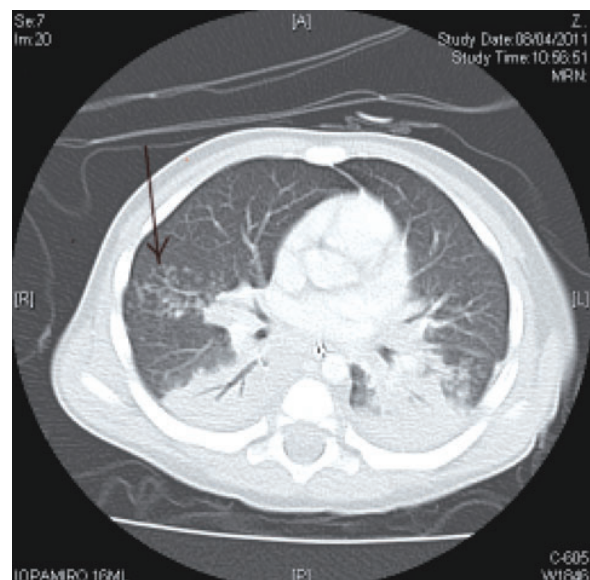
Day 13 CT. Thorax with contrast. Bilateral lower lobes airspace consolidation with air bronchogram. Centrilobular nodules were observed on right side (arrow).
